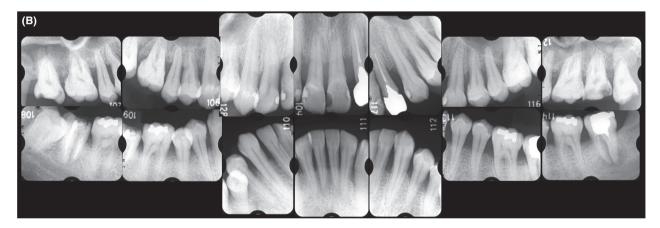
Periodontal examination and full mouth X-ray images taken of the patient before periodontal treatment. (A) The periodontal chart at the first visit revealed pocket probing depths that were significantly higher than normal with a rate of bleeding on probing (BOP)-positive sites of 98%, (B) radiographic evaluation revealed severe bone loss around the incisors and maxillary molars due to severe periodontal infection and traumatic occlusion (July, 2008).
